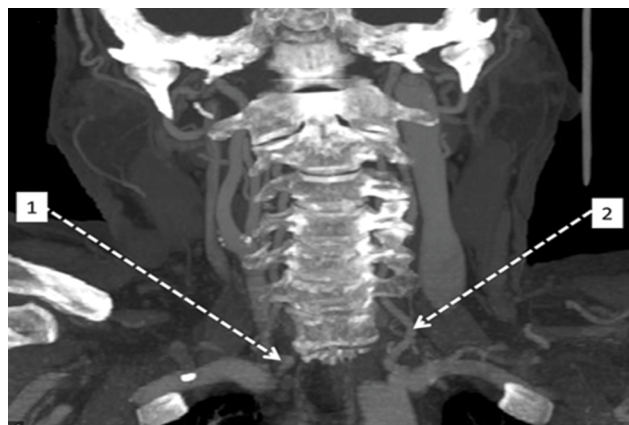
Bilateral V1 kinking VA (female, 72 years; CTA; volume rendering).
